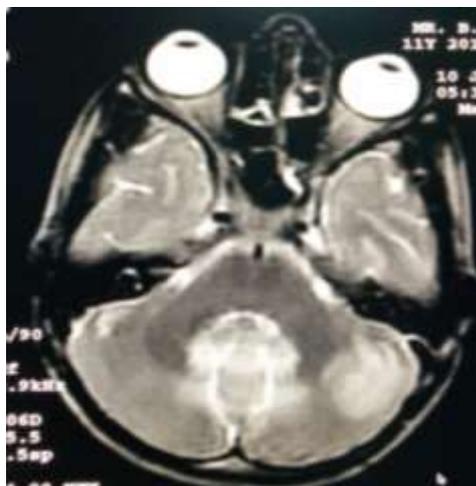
Coronal T2 MR images showing hyperintense lesions in left cerebellum
